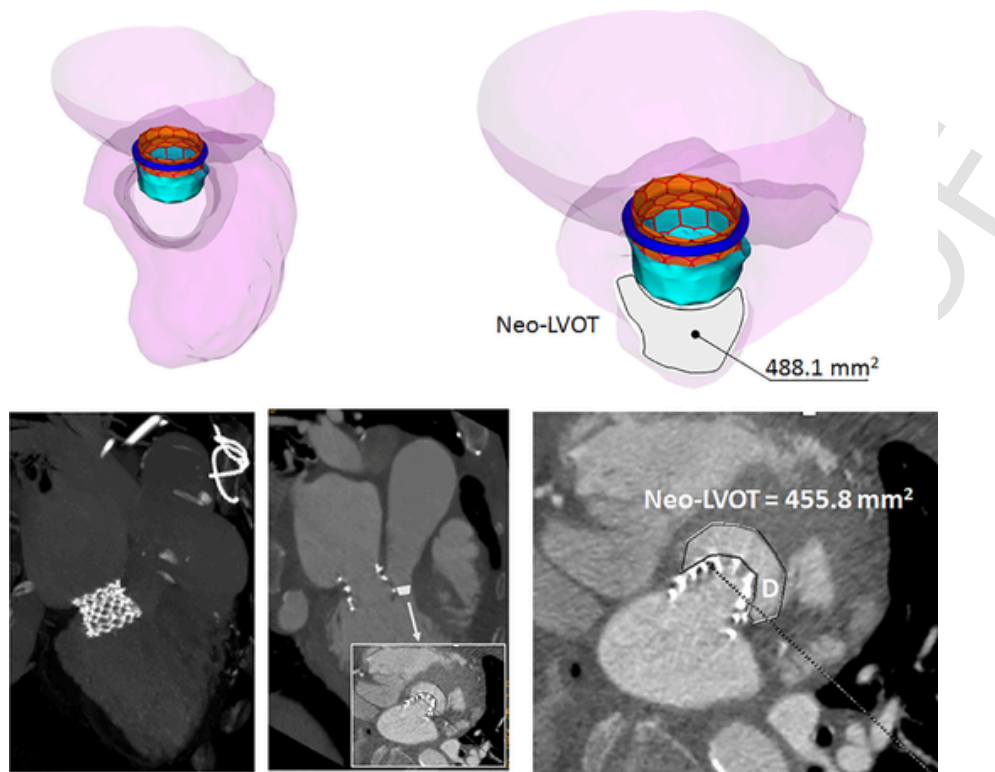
3D view of LVOT obstruction from the ascending aorta and corresponding neoLVOT area of Patient A (top) and post-TMVR CT measurements of neoLVOT area for Patient A.
